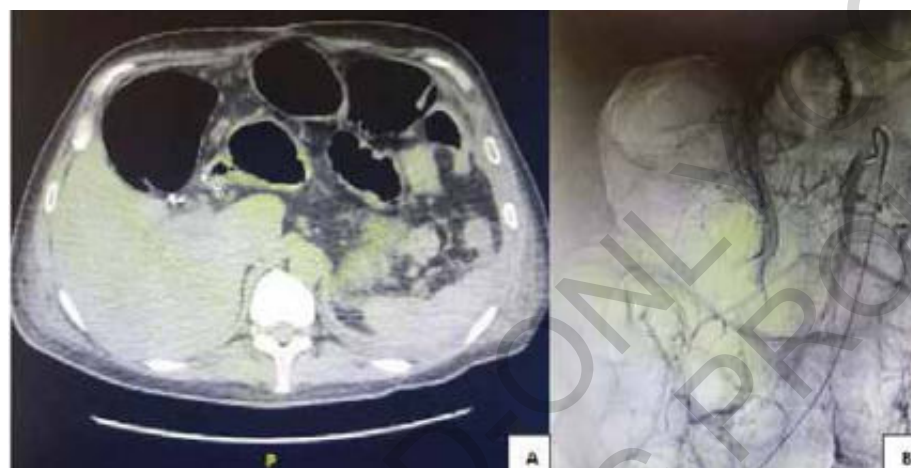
CT showing large and small bowel dilation without obstruction and a pancreatic artery ectasia (A). Arteriography showing normal vascular anomaly without active bleeding (B).
